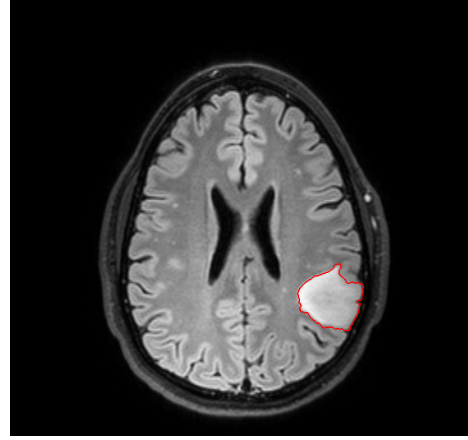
A manually contoured tumor on a FLAIR image of an IDH mutated glioma
